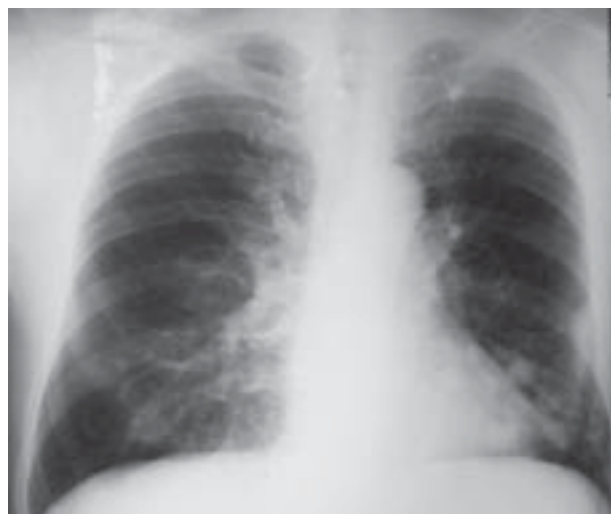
Chest X-ray from 2006, before ¹³¹I treatment with pulmonary metastases
